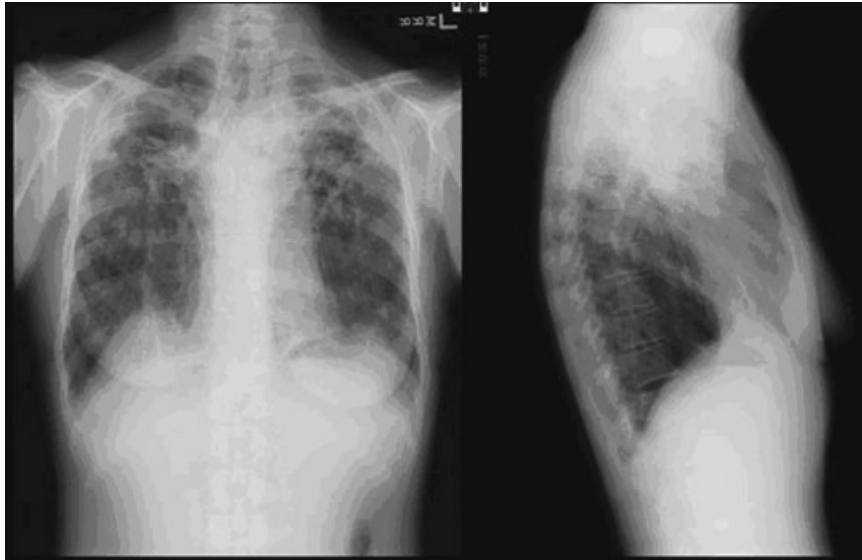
Stage III/IV radiographic sarcoidosis. Note the upper lung zone volume loss, upward retraction of the hila, and tenting of the hemidiaphragms.
